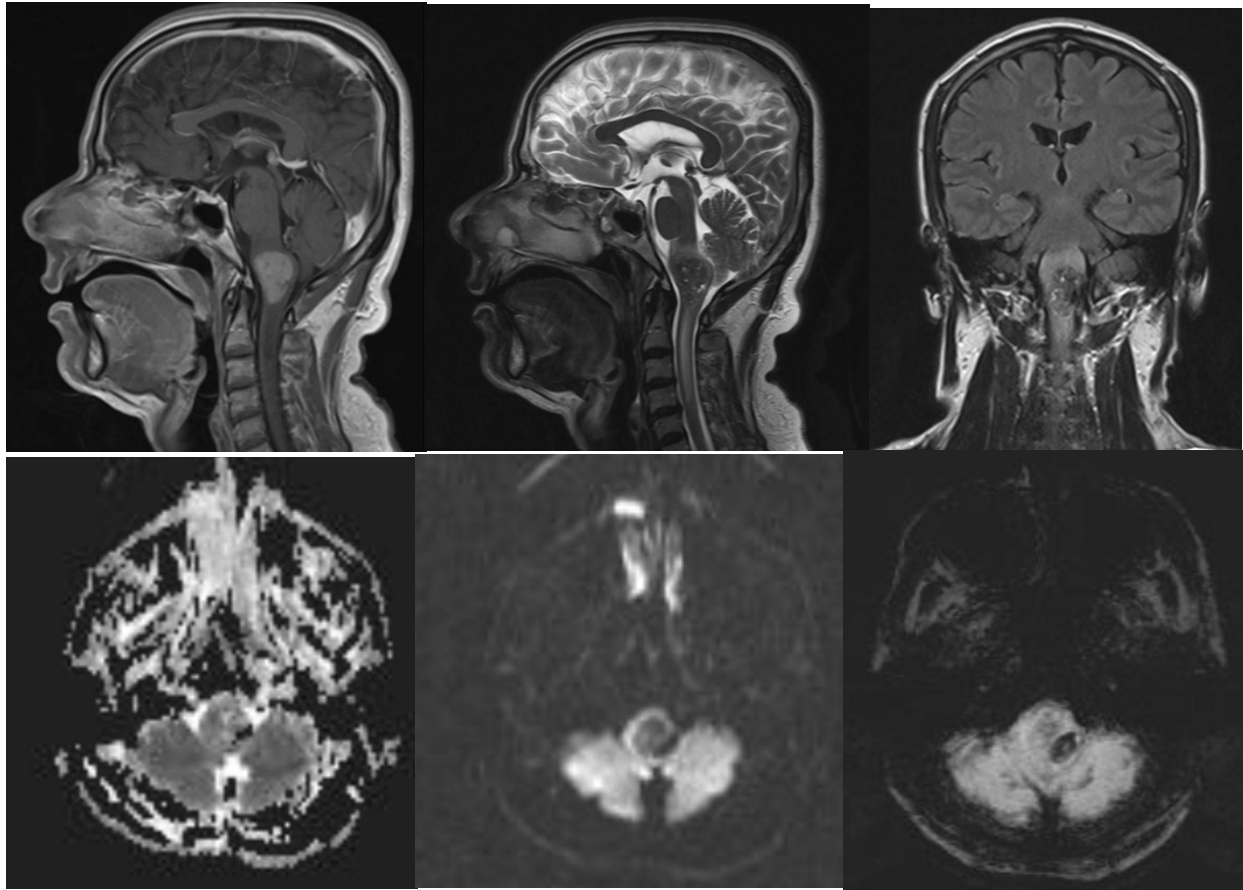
MRI images shows hyperintense lesion at brainstem medulla on T1 (A) which is hypointense on T2 with mottled hyperintensity. No diffusion restriction is seen in lesion. Areas of susceptibility dropout was noted along the left posterolateral aspect of the lesion representing hemorrhage.
